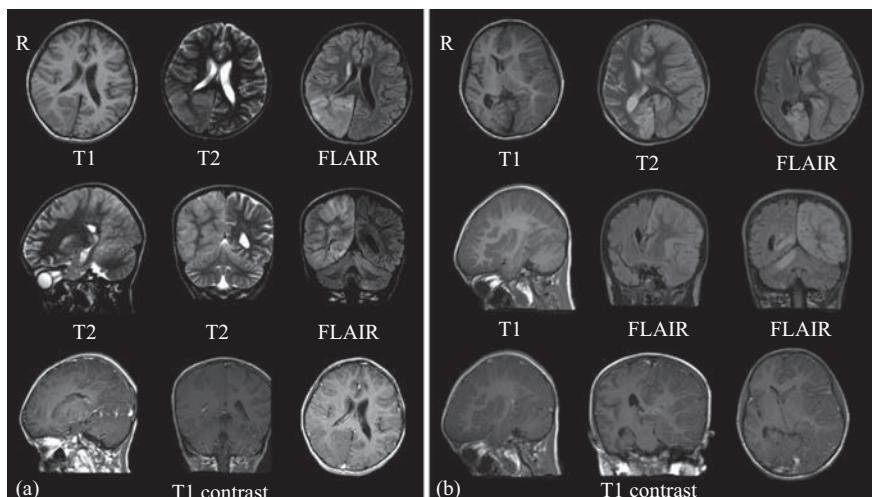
Brain MRI of a patient
